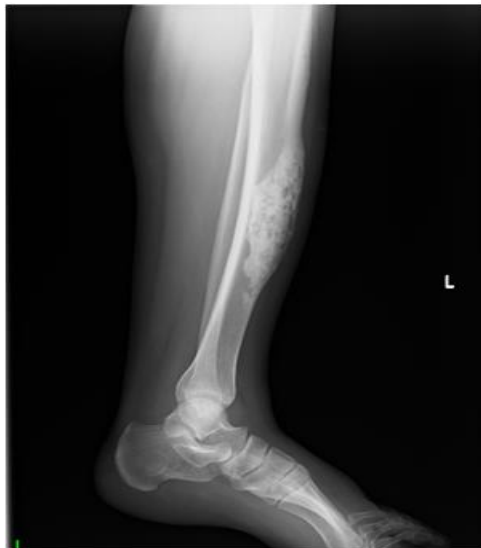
Radiograph showed an expansile multicystic lesion
